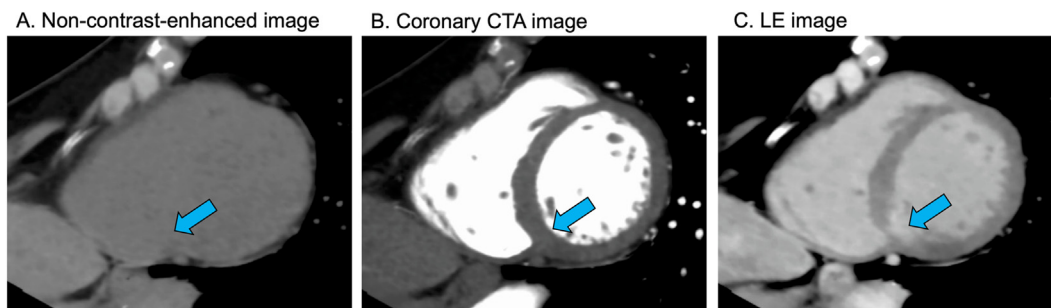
Recommended visual observation method for LE images. When observing with an image viewer, it is useful to align the left ventricular short-axis images of non-contrast-enhanced (A), CCTA (B), and LE (C) images together. The extent of LE lesion (arrows) can be evaluated by comparing LE images and CCTA images. Non-contrast-enhanced images can confirm that the LE lesion is not calcification. LE, late enhancement; CCTA, coronary computed tomography angiography.
